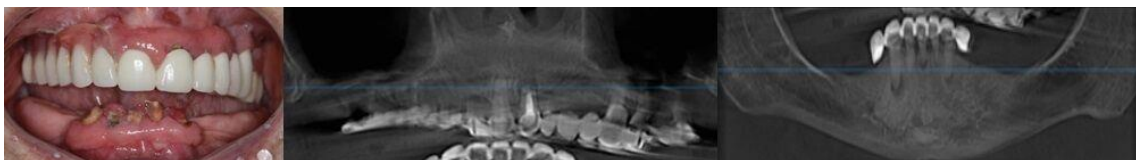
Initial status-clinical view, and radiograph
